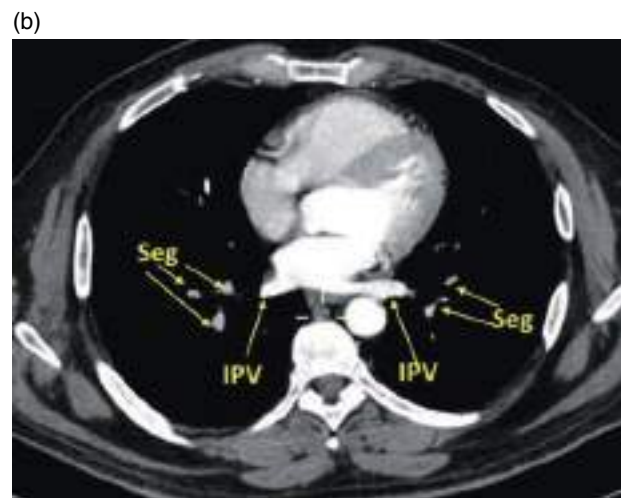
Basal segments of the right lower lobe. (a) Axial CT image (lung window). The four basal segments are shown, which in a counter-clockwise direction are the medial basal (M), anterior basal (A), lateral basal (L), and posterior basal (P). (b) Axial CT image (mediastinal window). Seg, segmental arteries; LV, lower pulmonary veins.
